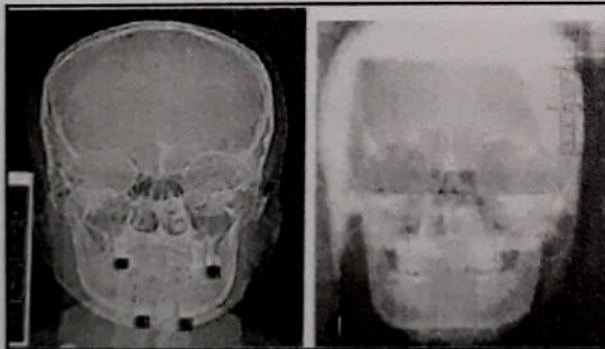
Measurement of mandibular height in CT and PA ceph.
